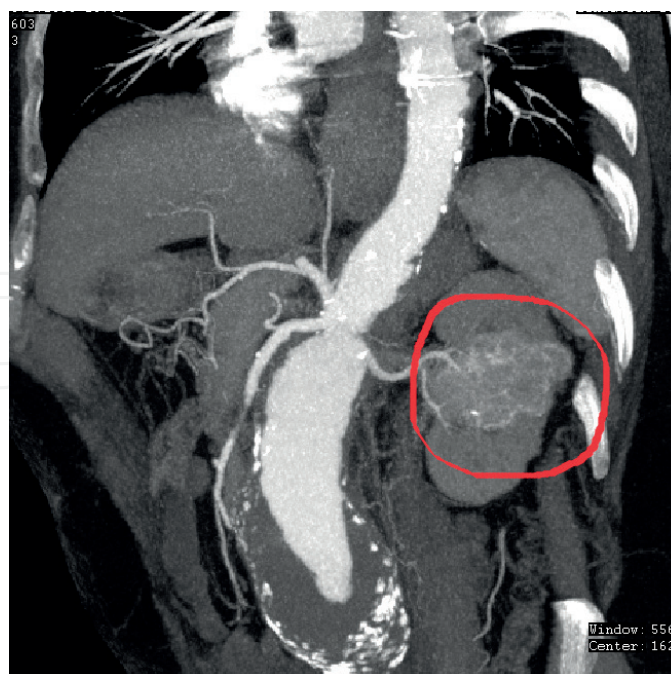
Juxtarenal AAA and renal cell carcinoma (CTA).
